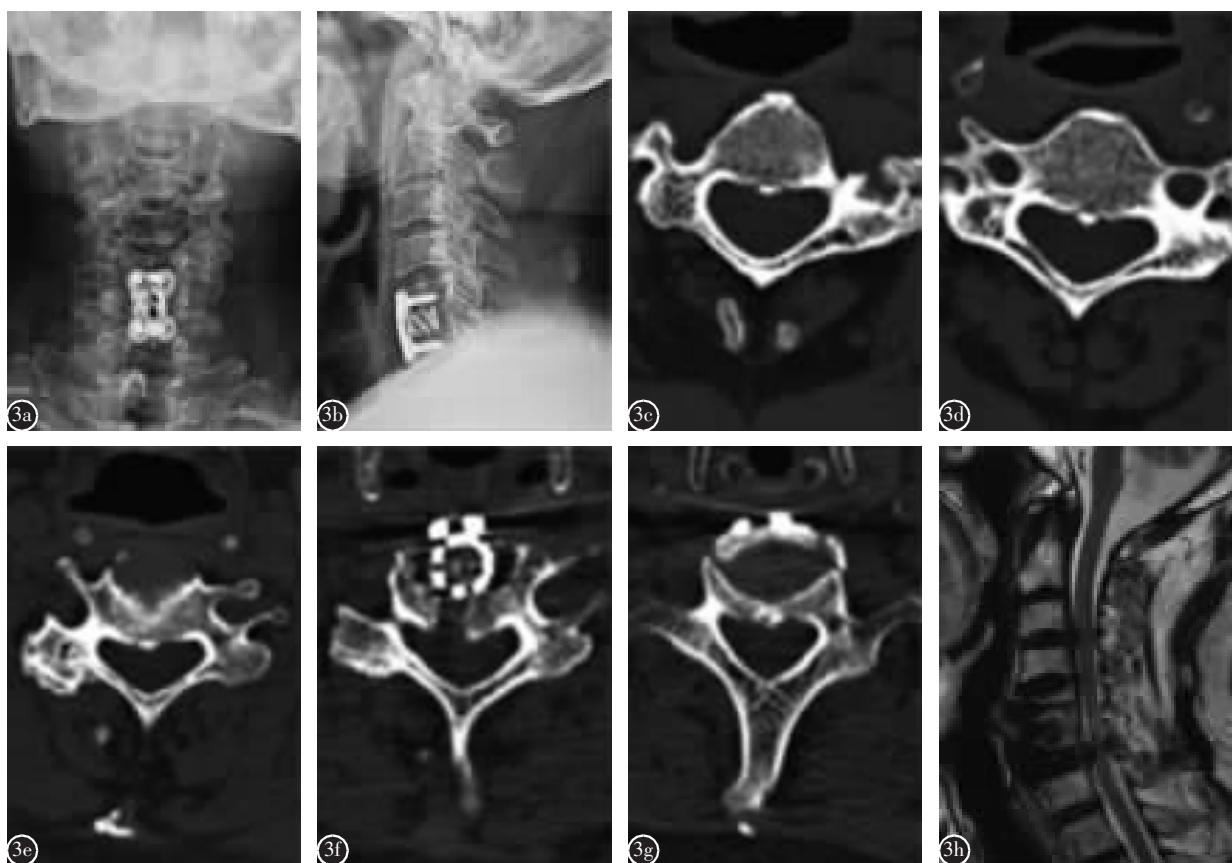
SCA-LP 组患者,70岁,男性,因 MCSM 住院行 SCA-LP 手术治疗,既往有颈椎前路椎间盘切除减压植骨融合术(anterior cervical discectomy and fusion,ACDF)手术史 a 术前 X 线正位片显示患者颈前路内固定术后 b 术前 X 线侧位片示颈椎生理曲度减小、C5/6 植骨融合 c~g 分别为术前 C3~C7 的 CT 横断面,显示颈椎管狭窄,C5、C6 最为严重 h 术前矢状位 MRI 示多节段椎间盘突出、C6/7 黄韧带增生皱褶脊髓受压明显
